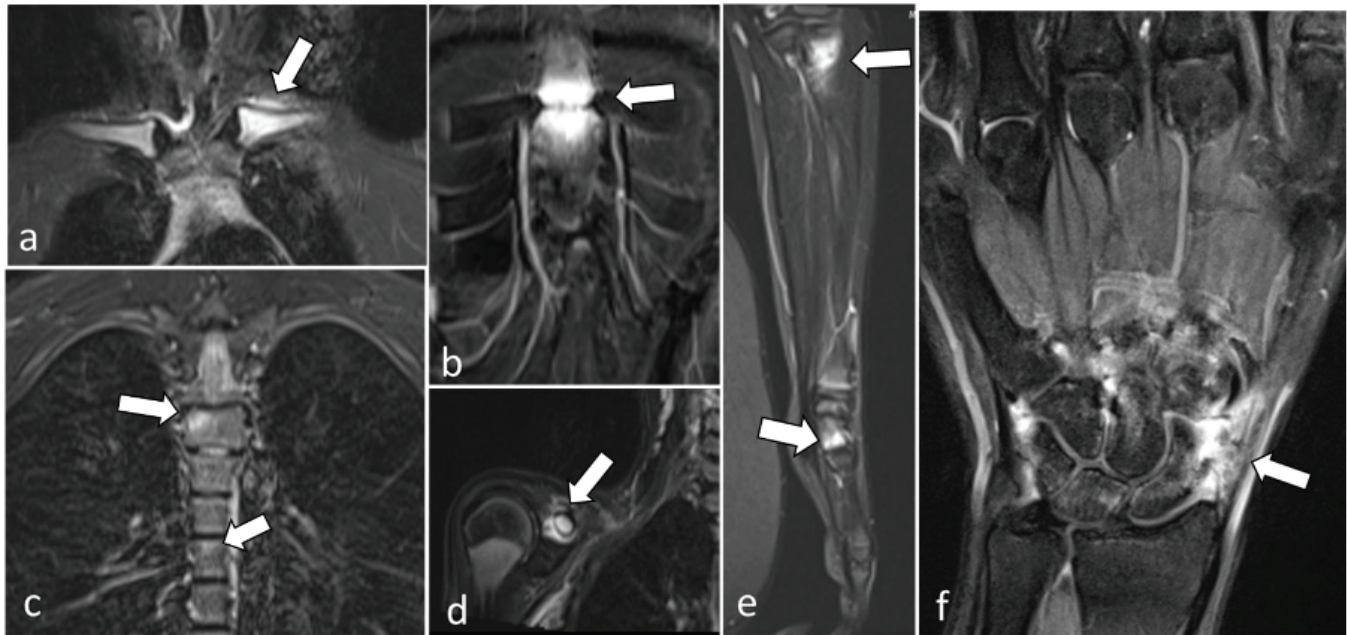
Whole-body magnetic resonance images of a 15-year-old male with axial skeleton and upper extremity involvement. Coronal STIR images show findings of osteitis in the metaphyseal areas adjacent to the physis line in the left clavicle (a), sternum (b), vertebrae (c), coracoid process (d), ulna (e) and carpal bones (e, f) STIR: Short tau inversion recovery
